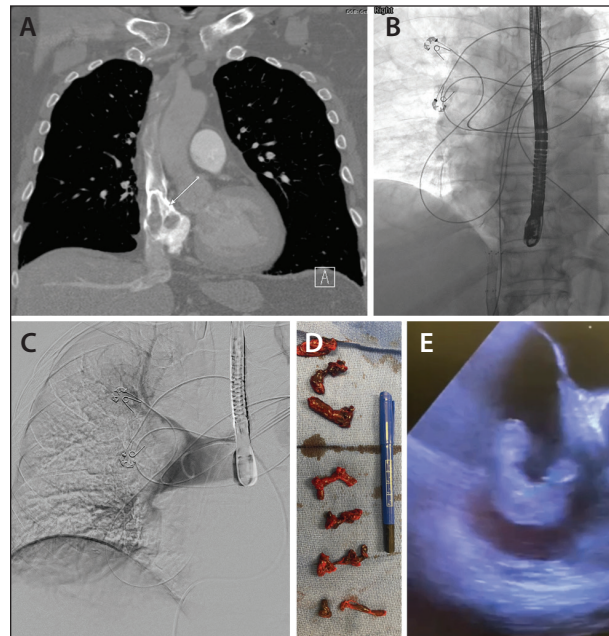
CTA demonstrating filling defects (arrow) within the RA (A). A 22-F AlphaVac cannula advanced to the RA under fluoroscopic and transesophageal echocardiographic guidance (B). Pulmonary angiography performed showing a right lobar PE (C). Thrombus retrieved within 1-2 passes with AlphaVac (D) and the corresponding echocardiogram of thrombus within the RA (E).
